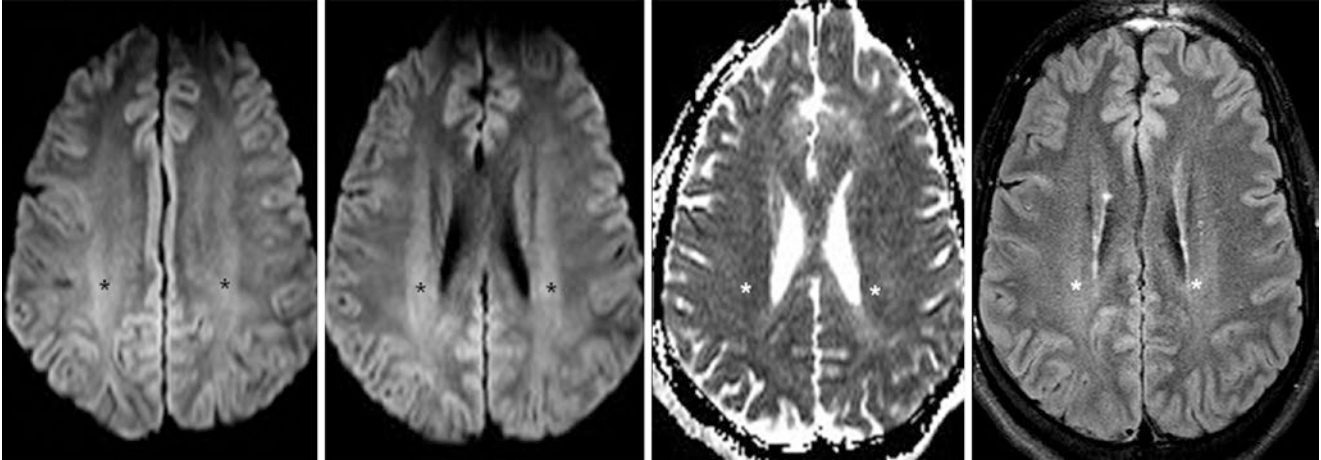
A 3 T MRI in a 27-year-old shows normal hyperintensity within the periventricular white matter (PVWM) (*asterisk*) bilaterally on DWI (*left*), with normal appearance on the ADC map (*right middle*). There is also mild hyperintensity on FLAIR (*right*)
